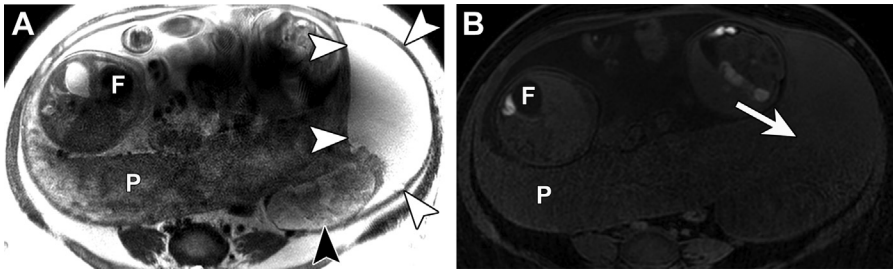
34-year-old woman with history of endometriosis presents with a large left adnexal mass in pregnancy. The mass was resected at the time of cesarean section delivery and found to represent a clear cell cancer. Axial T2-weighted image (A) shows a large cystic mass (*white arrowheads*) with a large solid component (*black arrowhead*). Axial T1-weighted image (B) does not demonstrate hyperintensity in the cyst fluid (*white arrow*), in contrast to Fig. 11. The mass and the solid component demonstrated exponential growth in pregnancy, which was suspicious for malignancy. F, fetus; P, placenta.
